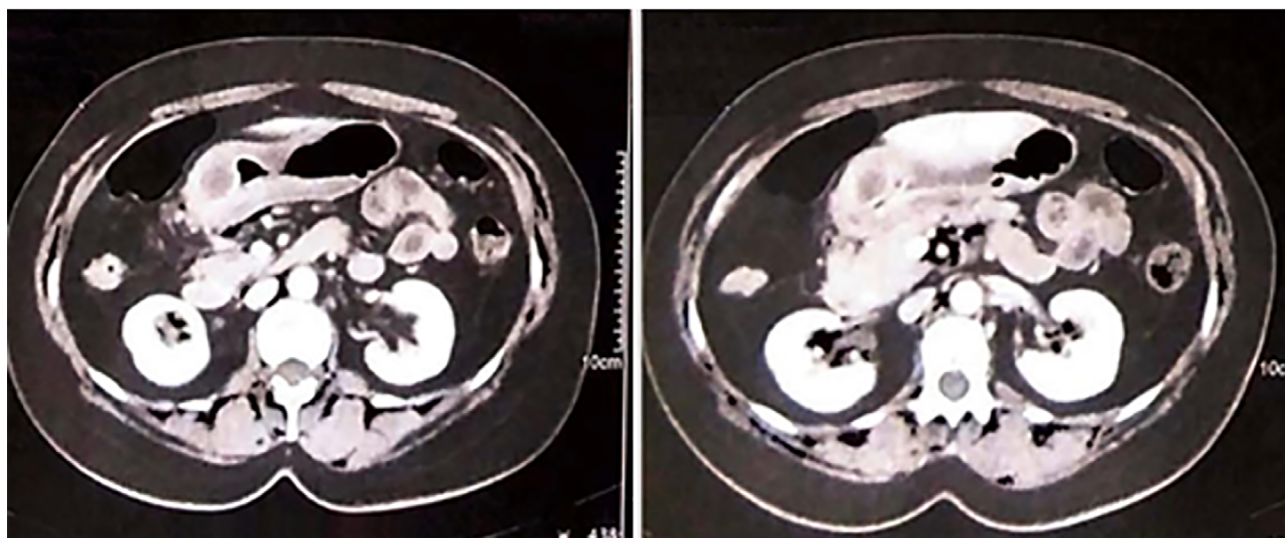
Computed tomography of the abdomen with circumferential parietal thickening in the distal gastric body and in the antral region, with a hypodense aspect and densification of the adipose planes in the duodenopancreatic sulcus. Reference: Radiology Service of Hospital SOCOR.
